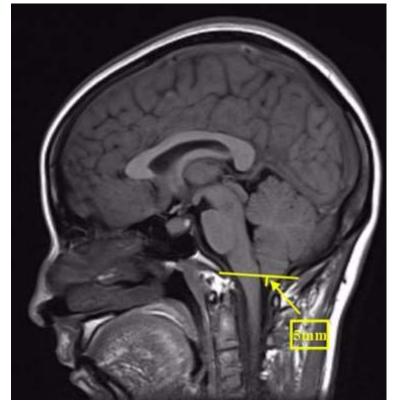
MRI Scan showing 'brain sag', typical of intracranial hypotension. Image: PLoS One. 2015; 10(4): e0123616 (Creative Commons Licence)
